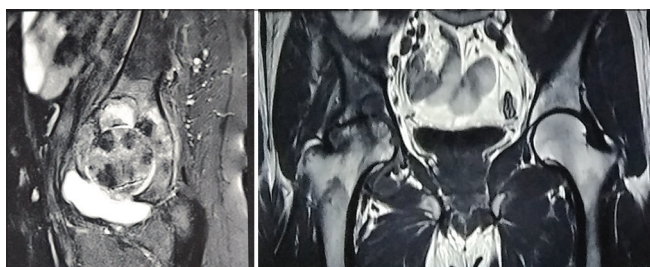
Sagittal T2-weighted fat-saturated and coronal T1-weighted magnetic resonance imaging sequences of a 45-year-old male with tubercular arthritis sequence show even thin synovial thickening of hip joint with marrow edema acetabulum and femoral head region and multiple subchondral lytic lesions with joint effusion visualized
